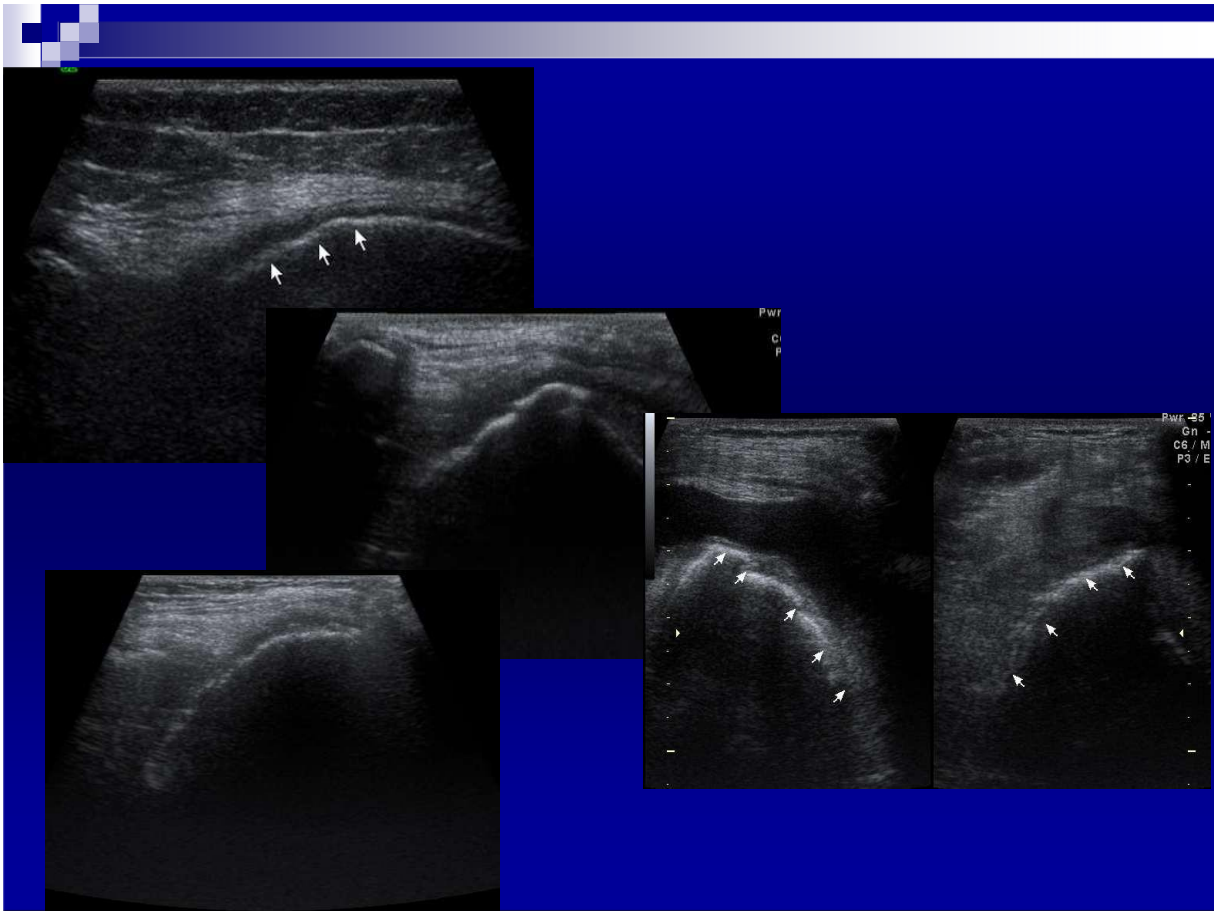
Grade III osteoarthritis on ultrasound examination of the knee joint. Significant thinning of the cartilage, presence of fluid in the joint, calcification, and multiple osteophytes on the joint surfaces can be seen
